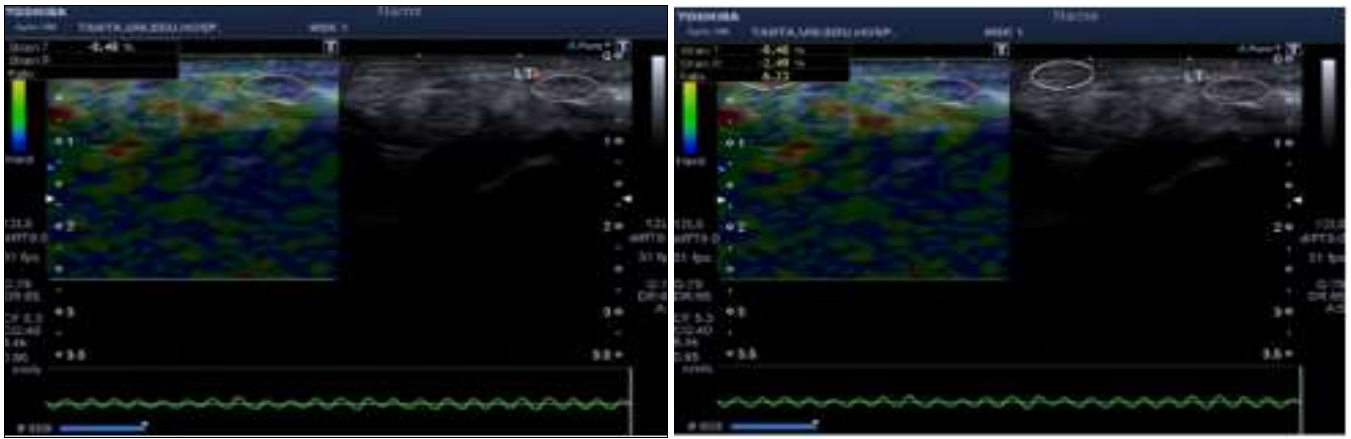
(A) Grey scale ultrasound showing right sever carpal tunnel syndrome and (B) Elastography ultrasound showing right sever carpal tunnel syndrome
